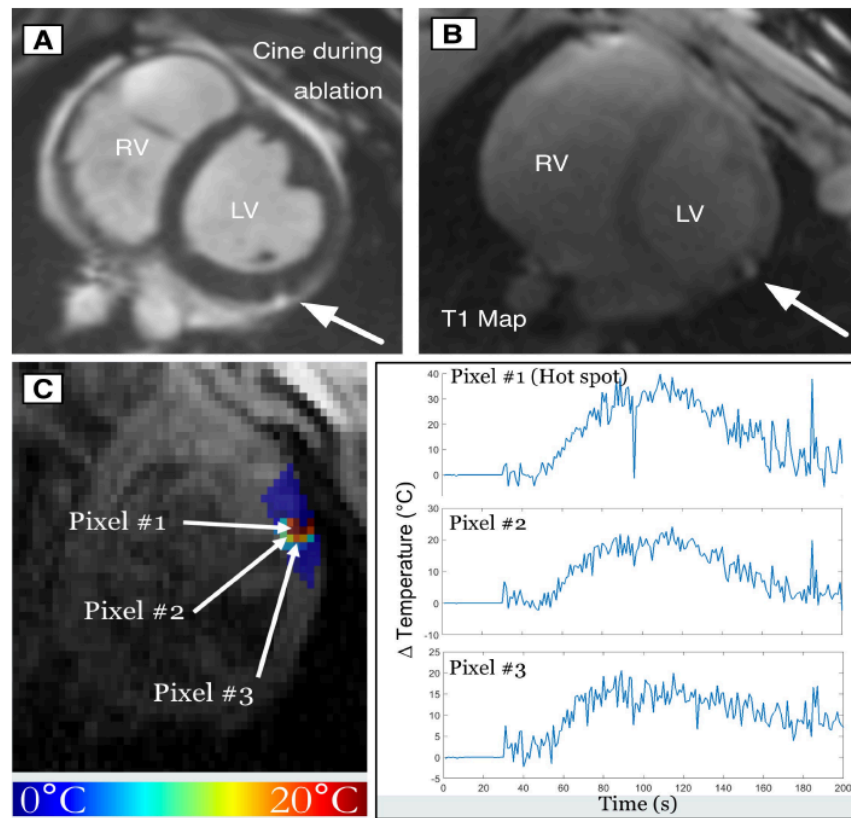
Acute and real-time MR imaging of lesion formation.
